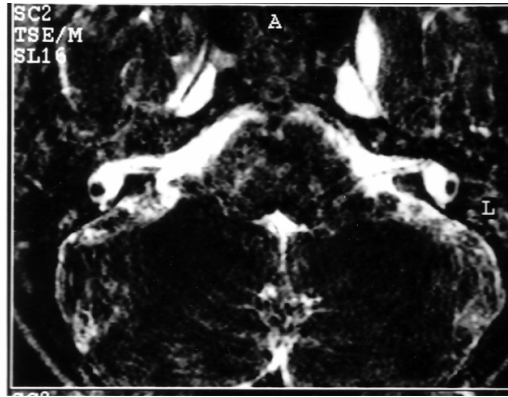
Axial 0.7mm T2 weighted MR image of IAMs showing existence of neural structures in both IAMs and leading upto a primitive common cavity.
